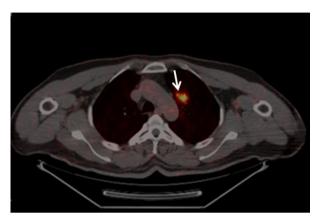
A Gallium-68 prostate-specific membrane antigen positron emission tomography/computed tomography scan of the patient performed in 2023 for restaging, showing an isolated metastasis to the left lung (arrow) with increased metabolic activity.
